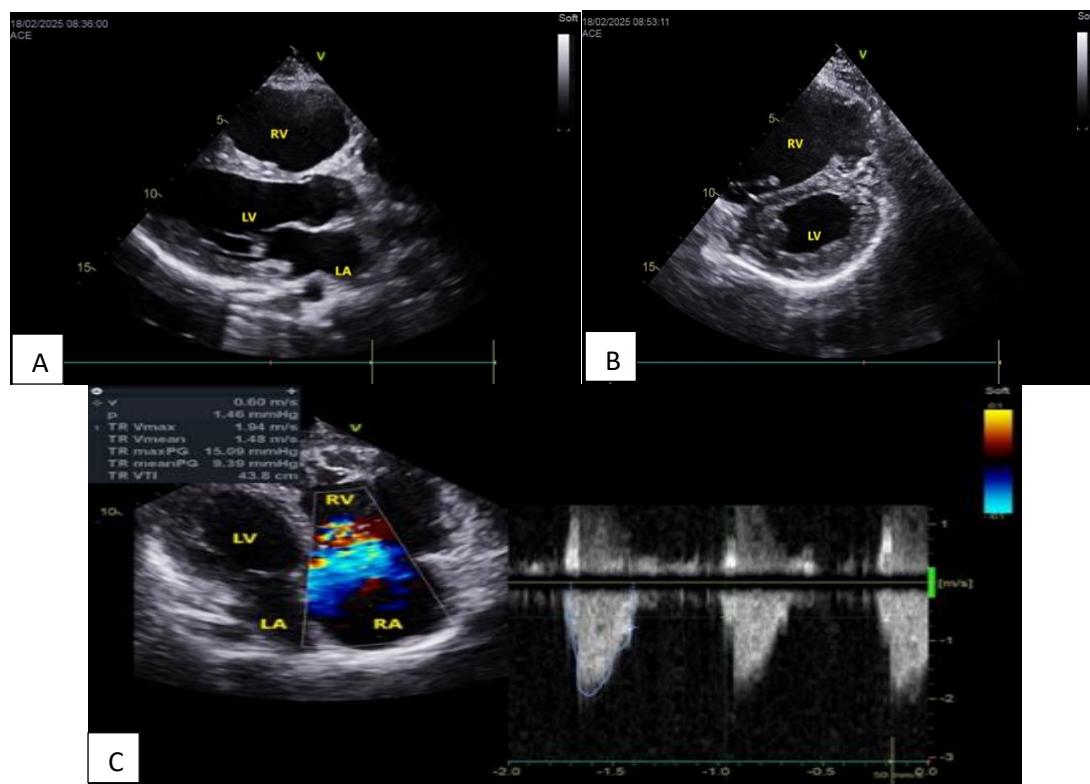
(A-C) The images of echocardiogram of patient 2 in the longitudinal, transverse and 4-chamber view.
